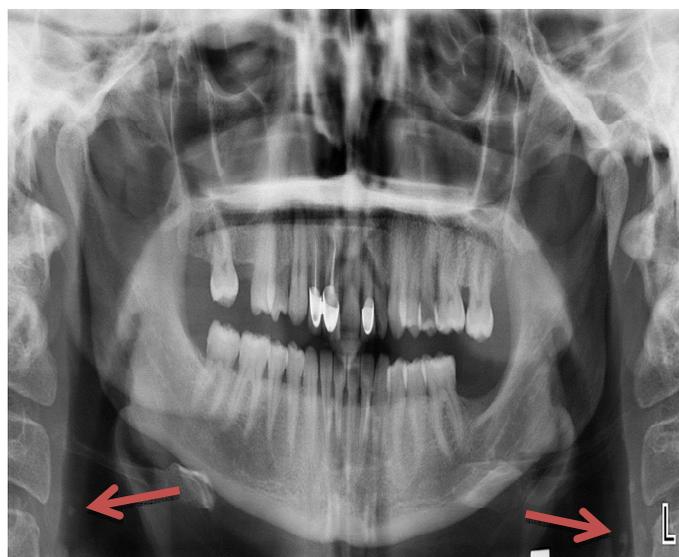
Panoramic radiograph showing carotid artery calcification
